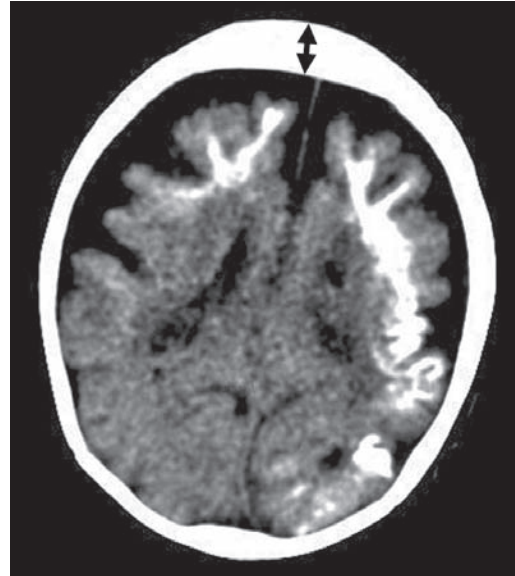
Sturge-Weber syndrome. Axial unenhanced CT scan of brain shows marked subcortical and cortical calcification in both cerebral hemispheres in a gyriform pattern. The calcification is more extensive in the left cerebral hemisphere. There is evidence of cerebral atrophy with enlargement of the surrounding CSF spaces and thickening of the skull vault anteriorly (black arrow)
